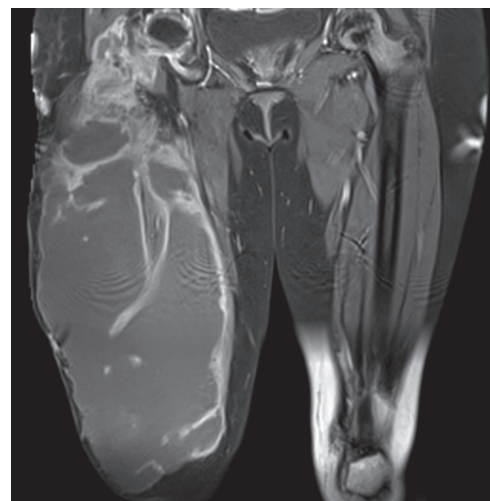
Axial T1-weighted magnetic resonance imaging (MRI) of right thigh revealed voluminous liquid collection involving all anterior compartment of the thigh with complete quadriceps musculature destruction
